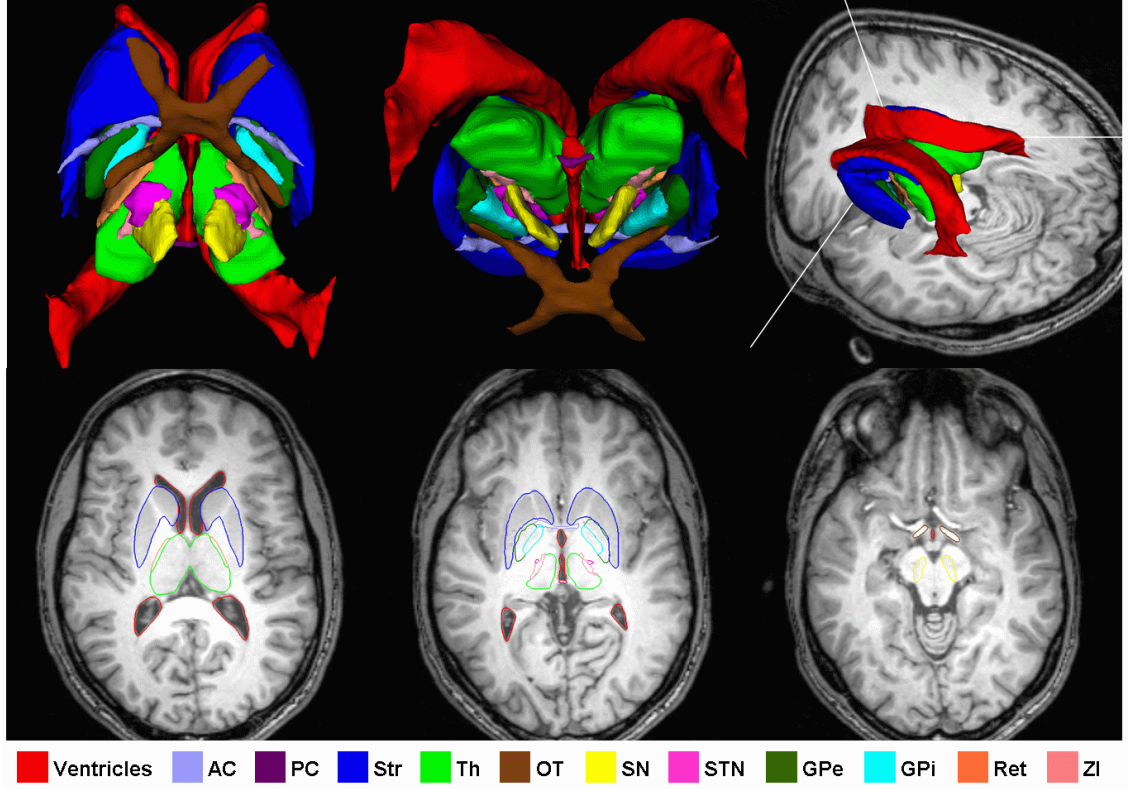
Manually segmented deep brain structures shown as 3D models (top row) and 2D contours (bottom row). Zoomed inferior view (top left image) and posterior view (top center image) of the 3D models of segmented deep brain structures in the atlas MR image. Segmented 3D models in 3D view (top right image) seen from superior-posterior side of the head. Bottom row shows three 2D axial slices along with the contours of the segmented deep brain structures. The abbreviations in the color coding at the bottom are defined in Section 4.1.3.
